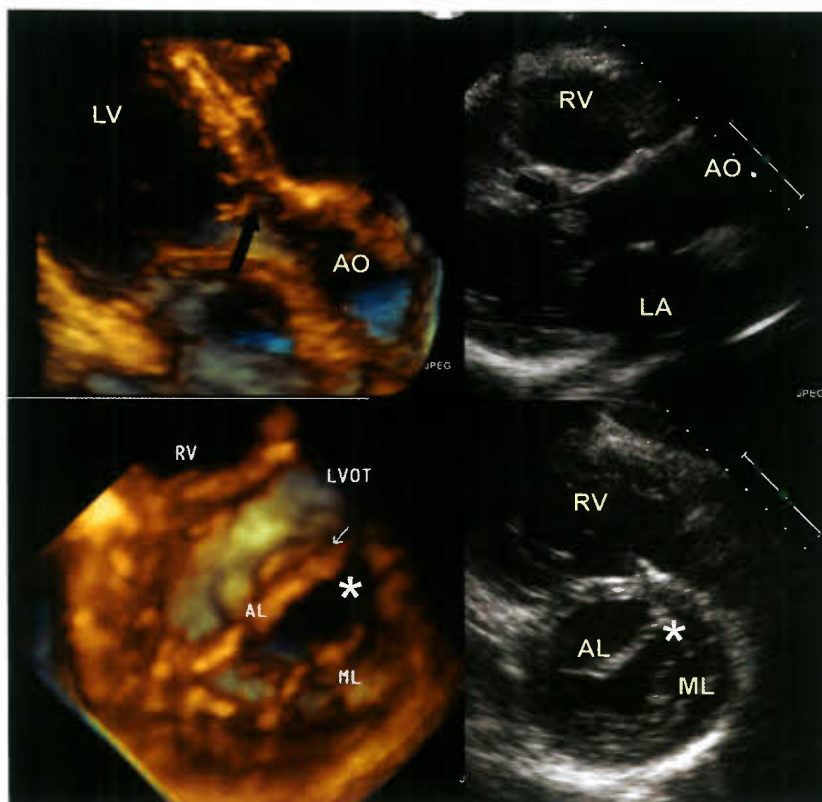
These images are from a case with a cleft in the anterior leaflet of the MV, with the cleft pointing toward the left ventricular outflow tract. The upper left hand image is a 3-D echocardiogram seen from the left atrium, with the cleft being indicated by the *black arrow*. The upper right hand picture is from the same case, but viewed from the left ventricular aspect. The lower two images are from the same case, with the left one showing the papillary muscle distribution and the right one the 2-D appearance of the cleft. The extent of the cleft is better appreciated in the 3-D images. AL, aortic leaflet; AO, aorta; APM, anterior papillary muscle; LV, left ventricle; ML, mural leaflet; PPM, posterior papillary muscle; RV, right ventricle.
